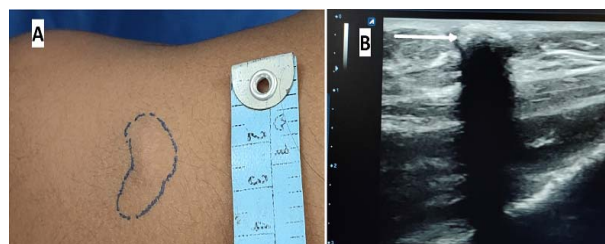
a) Crescent shaped left suprascapular swelling measuring 2.5x0.7 cm.; b) High resolution ultrasonography image showing subcutaneous, hyperechoic deposit with a linear morphology (white arrow) and acoustic shadow suggestive of calcific lesion.
